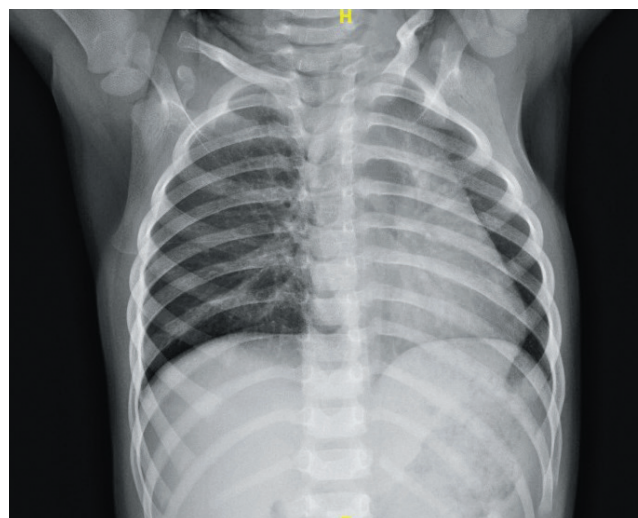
Chest X-ray showing hyperinflation on the right side with shift of the mediastinum to the left side.
